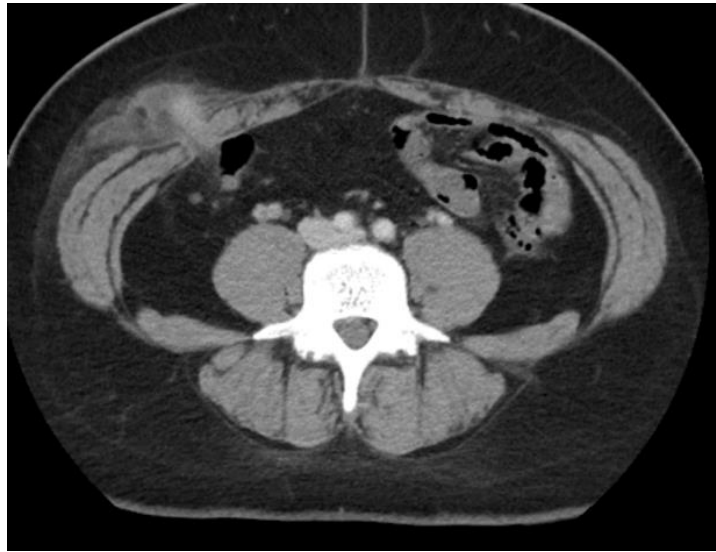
A section of the abdominal CT scan in the axial plane is depicted. It shows the appendix herniating through the Spigelian hernia defect on the right side.
